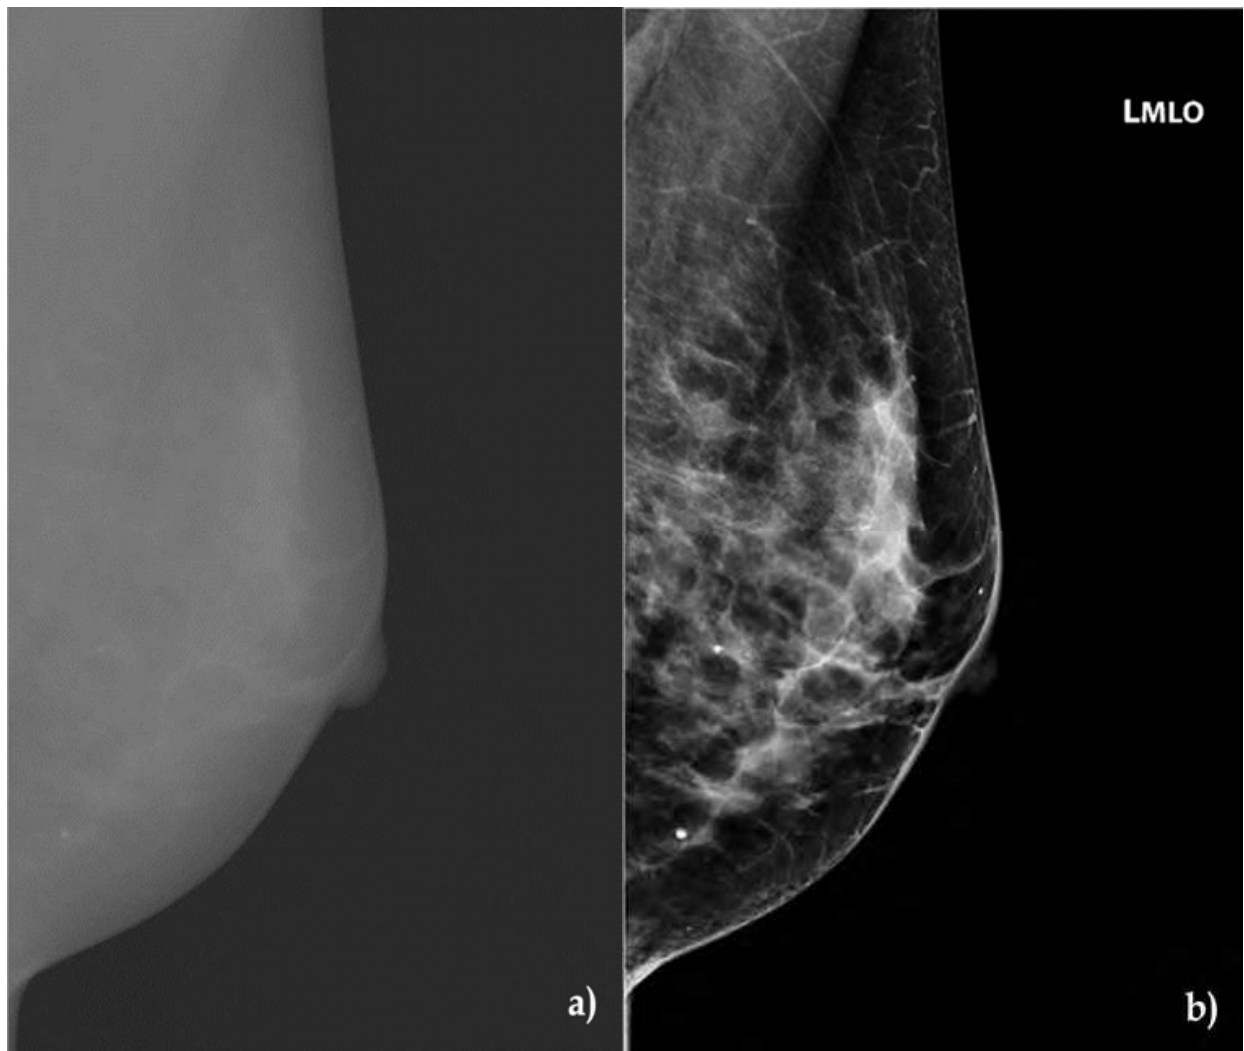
Digital mammogram. a) Raw image. b) Processed image. (Courtesy of Fujifilm Medical, Stamford, CT)
